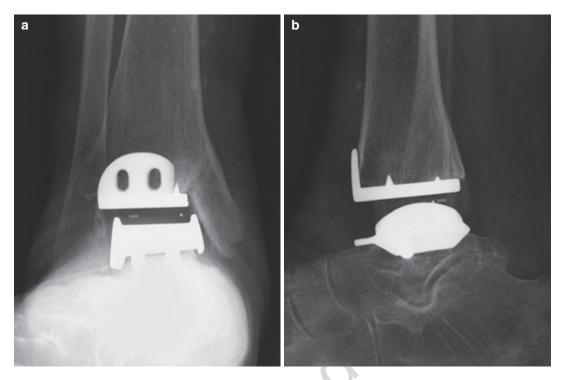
Ankle AP (a) and Lateral (b) view at the follow-up of 5 months. Medial malleolar stress fracture was seen on radiographs
